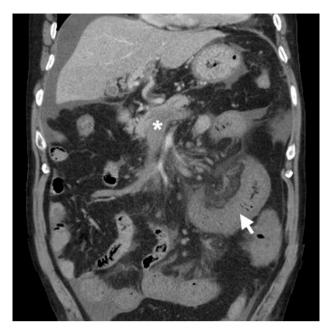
A coronary reconstructed view of multidetector-row computed tomography of the abdomen. Note the long segmental lower attenuation in the hepatic portal veins, splenic vein and superior mesenteric vein (white asterisk) together with edematous swelling and poorly enhanced long segmental small bowel loops (jejunum; white arrow).
